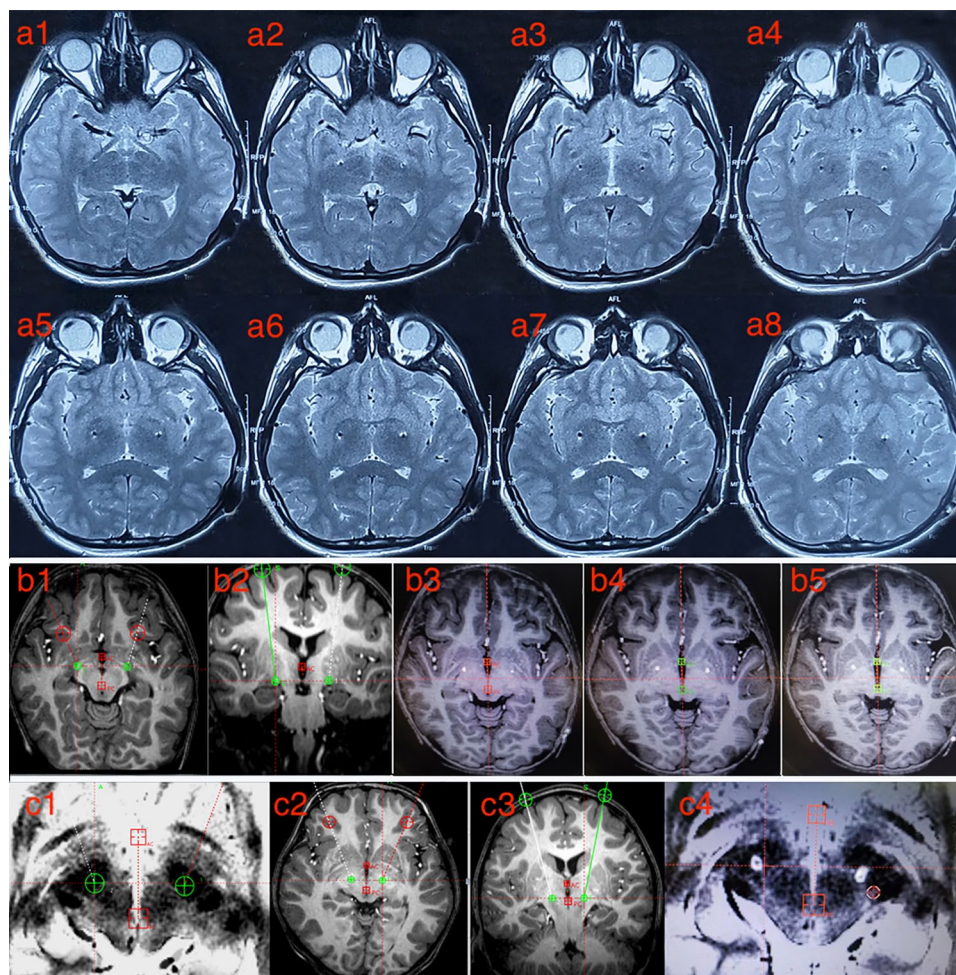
Pre- and post-operative images to confirm the electrode locations: (a1–a8) post-operative MRI (2-mm-layer thickness) for Patient 1 demonstrating the location of electrodes in the GPi targets. (b1 and b2) Presurgical planning of GPi targets for patient 2. (b3–b5) Post-operative computed tomography (CT) fused with pre-operative MRI showing the location of electrodes in the GPi targets. (c1–c3) Presurgical planning of STN targets for Patient 3. (c4) Post-operative CT fused with pre-operative MRI showing the location of electrodes in the STN targets.
